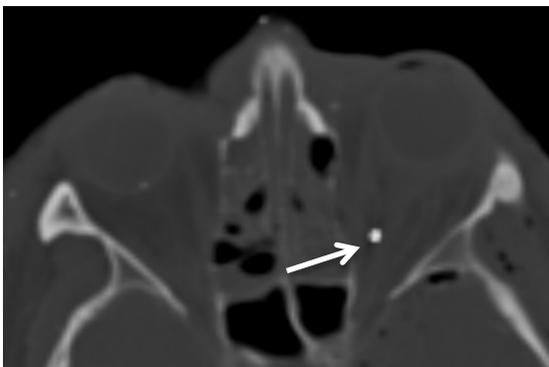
Metallic foreign body (white arrow) in course of left optic nerve (40-year-old male with complete vision loss). CT, axial section: The optic nerve is transected.
